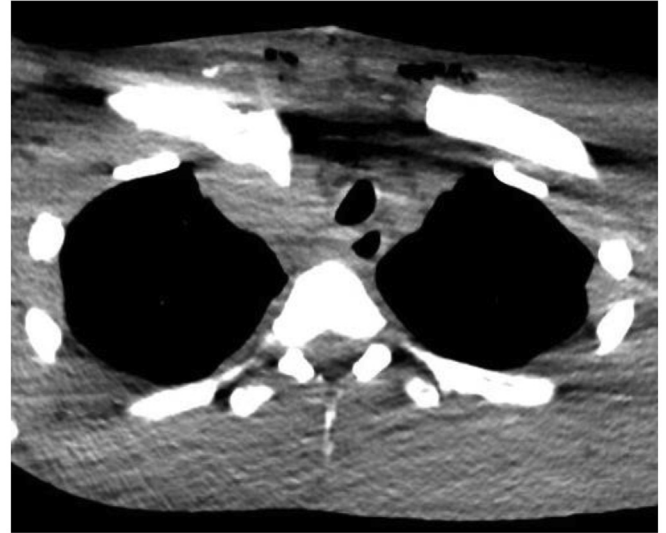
Computed tomography angiogram showing a Salter-Harris I fracture of the right clavicular head with 1.5 cm of posterior dislocation and evidence of bone resorption and healing and surrounding contusion/hematoma.
